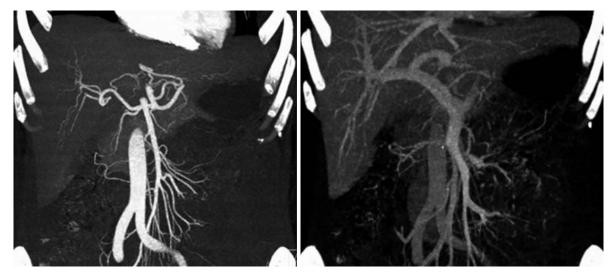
Coronal MIP image of the mesenteric vasculature (left) and the portal venous system (right) obtained on a 64 row CT scanner
